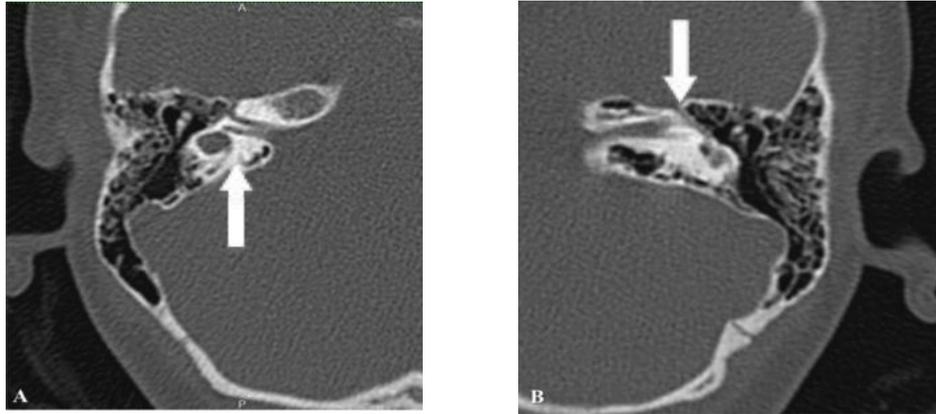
Preoperative CT scan of the temporal bone (axial plane)
